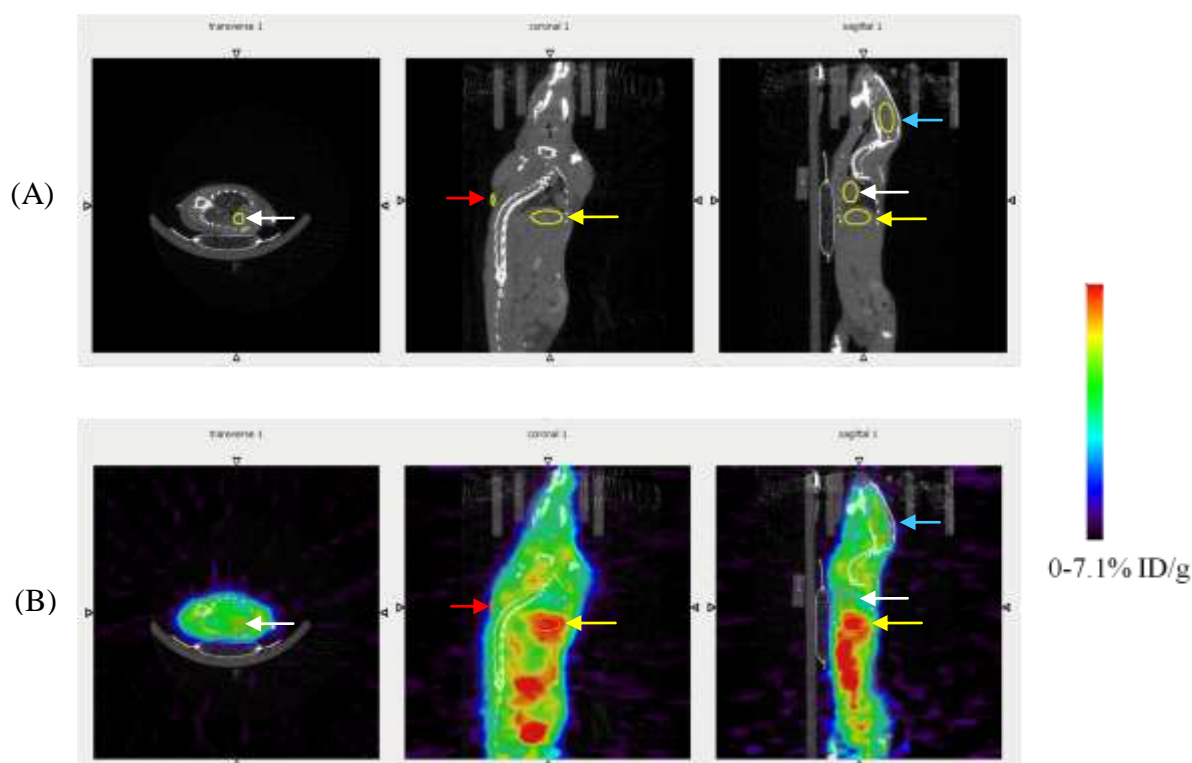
Dynamic PET image 65-66 minutes pi: ROIs for tumour (coronal view, red arrow), brain (sagittal view, blue arrow), heart (sagittal view, white arrow) and liver (coronal and sagittal views, yellow arrow). (A) CT image (B) PET/CT image. PET colour indicating 0-7.1% ID/g
